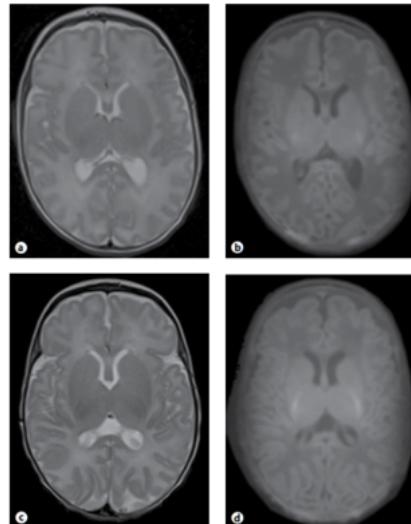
Representative T2-weighted (a, c) and T1-weighted (b, d) MRI at TEA. a, b Infant 1, GA at birth 30 0/7 weeks, scanned at 40 3/7 weeks. TMS: 11.5 (myelination: 2.5, cortical folding: 3, germinal matrix: 3, bands of migrating cells: 3). c, d Infant 2, GA at birth 30 1/7 weeks, scanned at 40 4/7 weeks. TMS: 17.0 (myelination: 5, cortical folding: 4, germinal matrix: 4, bands of migrating cells: 4).
